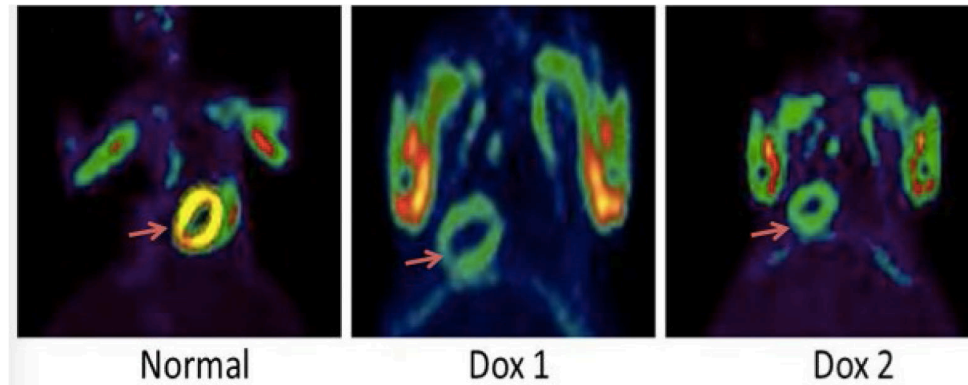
Myocardial metabolism imaging by ^{18}F FDG-PET
